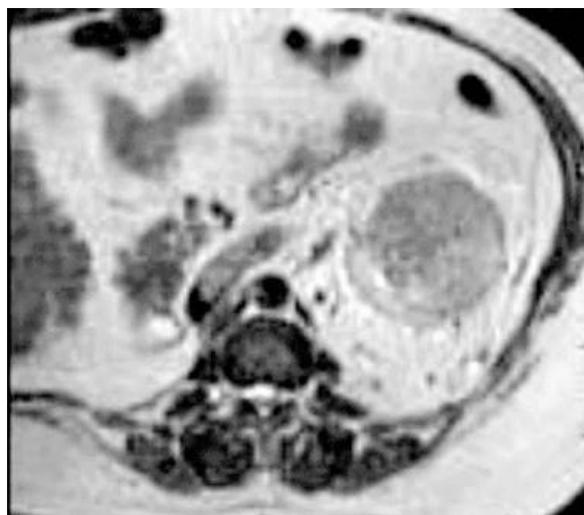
Left renal cell carcinoma - T2-weighted axial MRI image with renal vein invasion and extension of tumor into the inferior vena cava.
